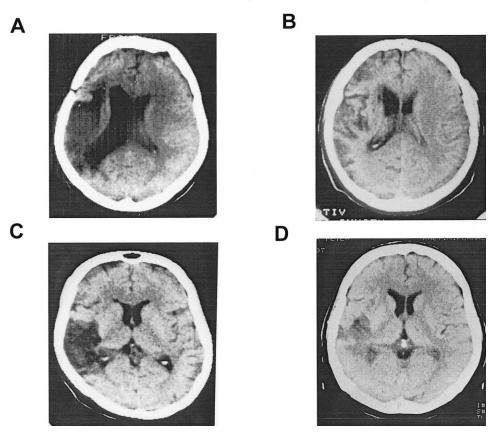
CT scans of the four patients investigated (for details see text).
